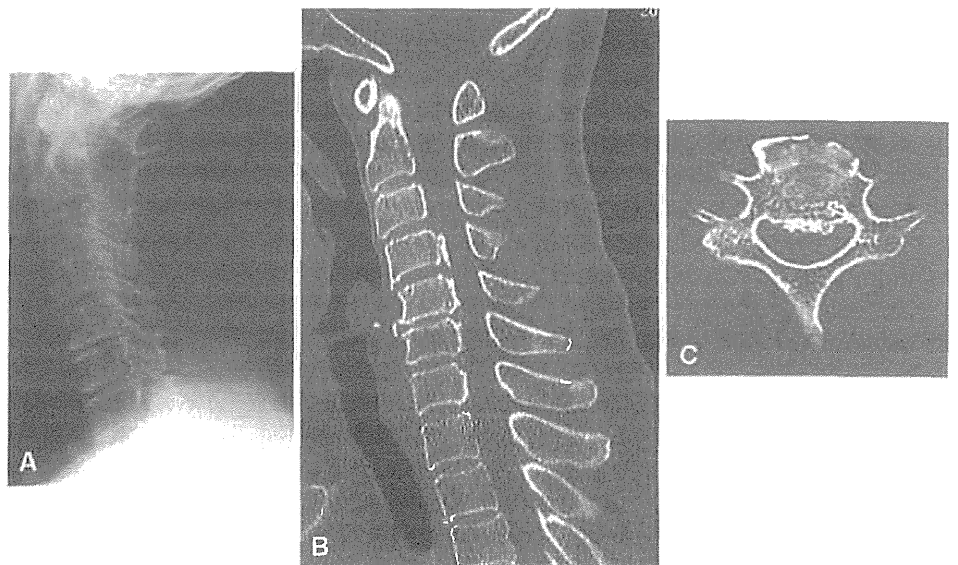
A 69-year-old woman. Lateral cervical X-ray (a), midsagittal computed tomography (CT) (b), and axial CT at C5 level (c)
